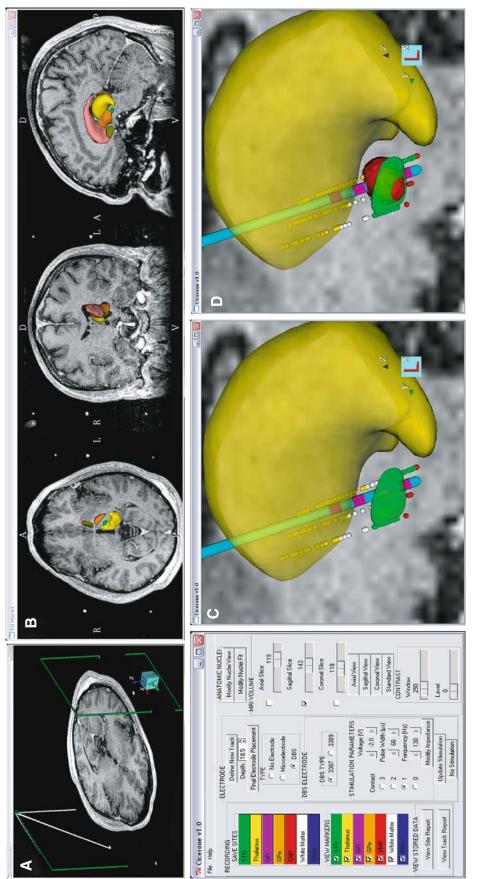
Human Cicerone graphical user interface. (A) The green localizer box is manipulated to coincide with the stereotactic frame fiducial markers in the MRI. (B) A 3D brain atlas is customized to the subject's MRI with interactive scaling and translation. (C) Microelectrode recording data (yellow dots thalamus; white dots white matter; green dots SNN; red dots SNN; and the DBS electrode position (blue shaft with pink contacts) can be viewed in stereotactic space with the MRI and anatomical nuclei (vellow volume thalamus; green volume STN). (D) Theoretical predictions of the volume of tissue that would be activated by DBS (red volume) can be visualized with any electrode position/trajectory and a range of stimulation parameter settings developed our human Cicerone system to directly read in and interact with DICOM imaging data via a simple user interface; thereby decreasing the time needed to set up the system. When the user starts the program, they are prompted to enter any necessary patient/study identification data. Next, they navigate to the appropriate directory and load the patient's DICOM imaging data. A fundamental requirement of any stereotactic neurosurgical navigation system is the definition of a common coordinate system. In turn, the user must position a virtual replica of the frame fiducial system within the context of the MRI; thereby defining the stereotactic coordinate system relative to the imaging data (Fig. 1A). Version 1.0 of Cicerone has been designed to work with the Leksell stereotactic frame (Elekta Corp., Stockholm, Sweden). Following definition of the stereotactic frame coordinate system in the MRI, the user is prompted to select the right or left side of the brain for analysis. The user then orients the MRI along the midline using coronal and axial views, and defines the anterior commissure (AC) and posterior commissure (PC) in the image. The next step in the process consists of scaling and positioning 3D anatomical representations of nuclei of interest (e.g. subthalamic nucleus, globus pallidus, thalamus, etc.) (Fig. 1B). The anatomical nuclei are originally positioned within the context of the MRI based on the definition of the AC and PC. However, the user has the option to translate and/or scale the anatomical nuclei along the anterior/posterior, dorsal/ventral, and medial/lateral axes to enable the most accurate match possible with the MRI (Fig. 1B).
